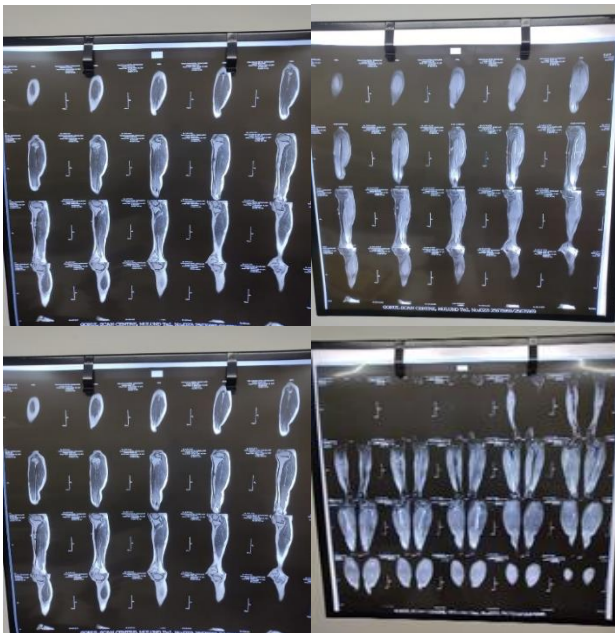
MRI of proximal tibia.
